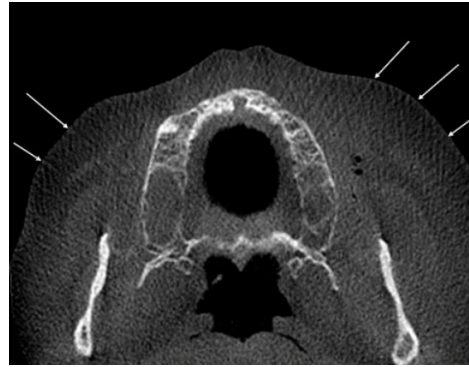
Typical aliasing patterns in CBCT data sets. The lines (arrows) diverge from the centre towards the periphery and are most probably caused by the undersampling owing to the cone beam geometry.
